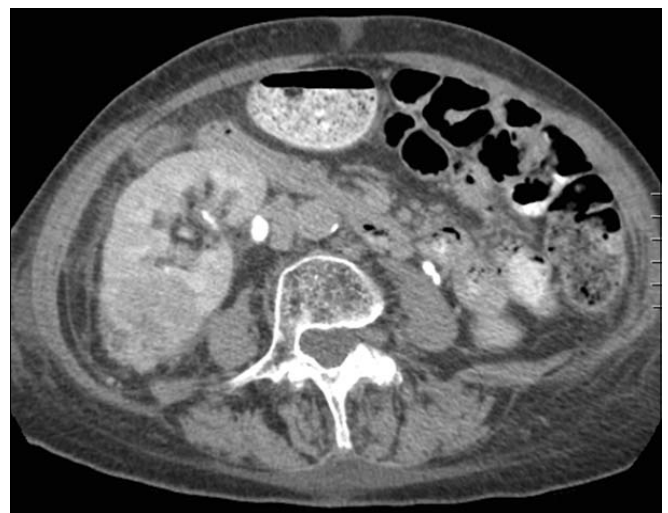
Transverse section of a computed tomography urogram showing a heterogeneous parenchymal right exophytic renal mass suspicious of renal cell carcinoma.
